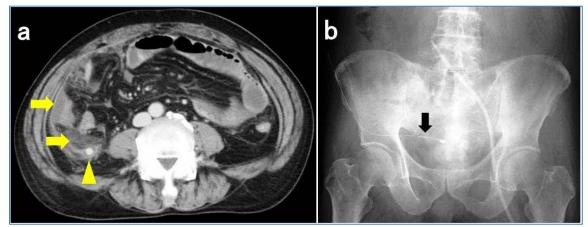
Case 2. (a) Abdominal computed tomography showed a swollen appendix with a fecal stone (*arrow head*) and an inflammatory status with fluid collection around the cecum (*arrows*). (b) Percutaneous abdominal drainage tube (*arrow*) was inserted.
